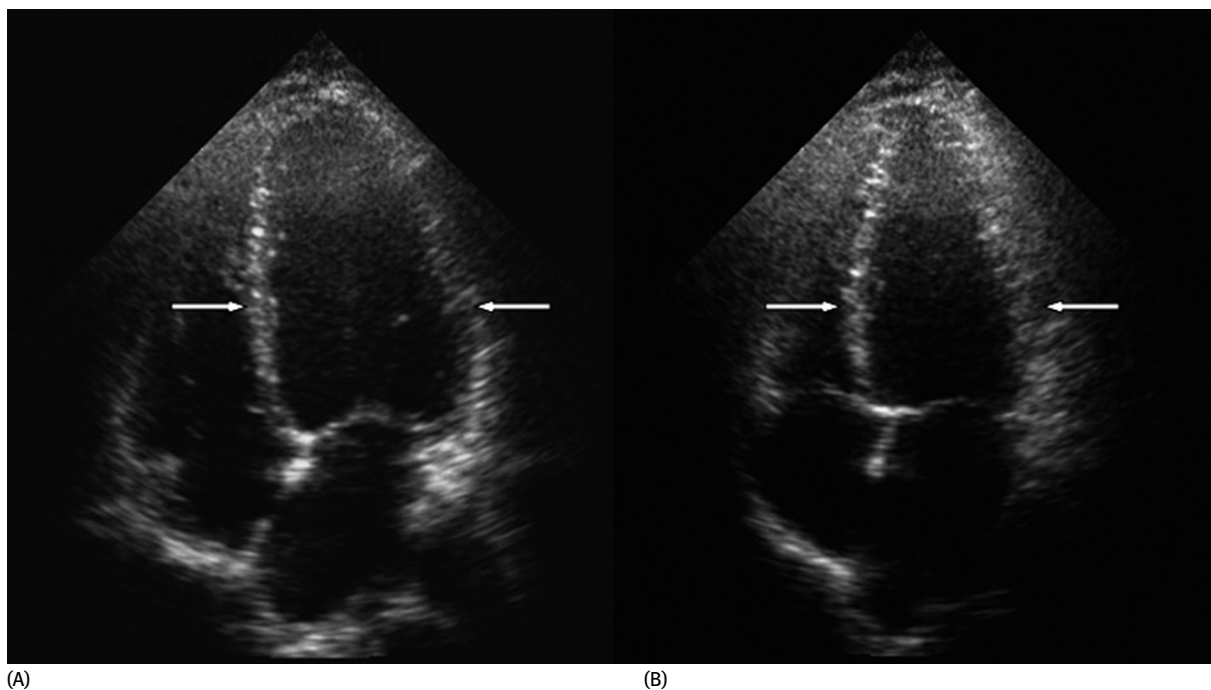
Apical 4-chamber view of transthoracic echocardiogram demonstrating hypokinesis of the basal segments (arrows) with preserved function in the apical segments. (A) diastole; (B) systole.
